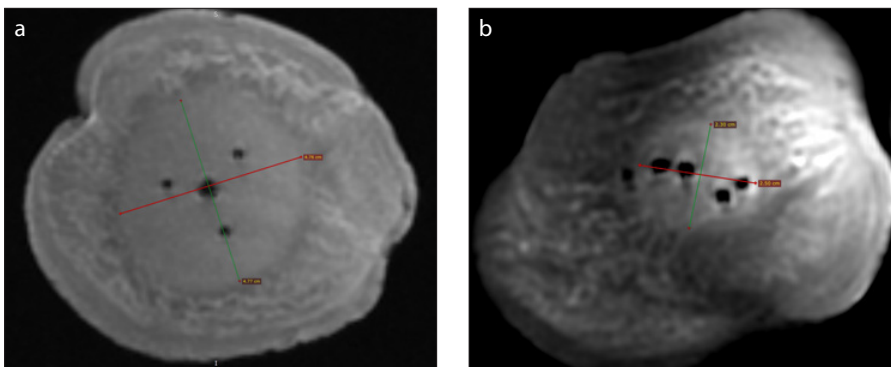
a, b. Magnetic resonance images of the ablated tubers. In this case, with Embozene 500 injected into the center of the ablation zone. Three-probe experiment (a) and two-probe experiment (b).
